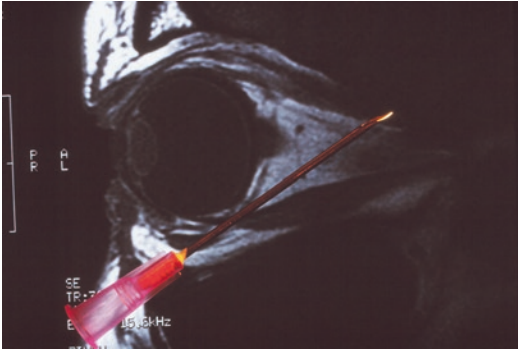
A 22-gauge needle superimposed on an orbital MRI. In order for the needle to clear the inferior orbital rim and the bottom of the globe, it can only impale the SR near the apex of the orbit, as has been shown by Capo and Guyton [18] (from Kushner [19], with permission)
